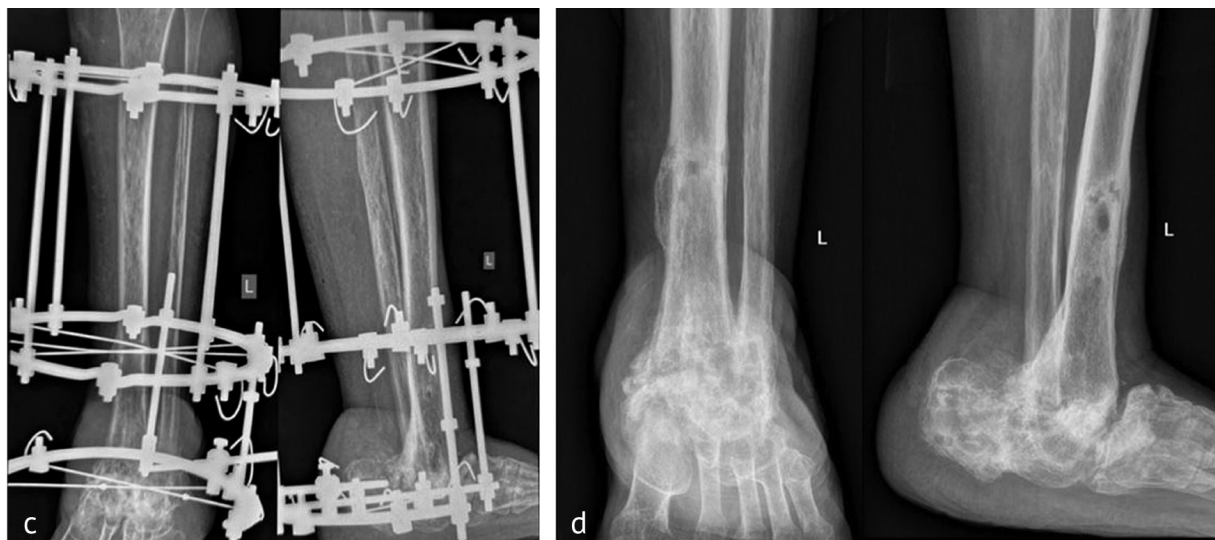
(continuation) Series of left ankle X-Rays during the course of treatment: (c) at the time of frame removal; d 6-month follow-up
